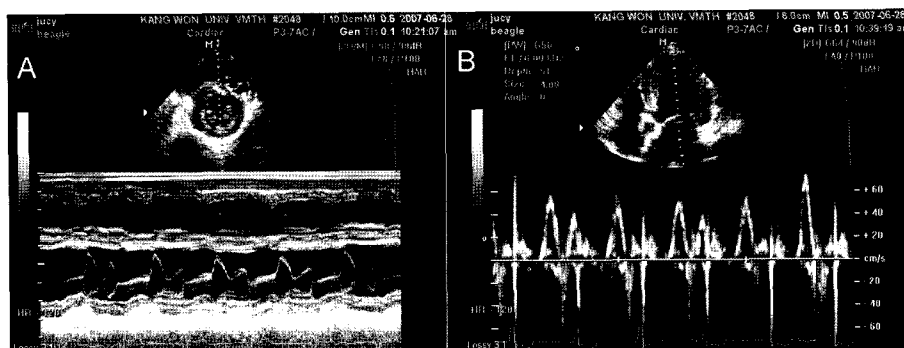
Echocardiography taken after pacemaker implantation. A: The M-mode echocardiogram showed regular and consistent left ventricular contraction. B: Spectral Doppler echocardiogram showed consistent coupling of E and A wave. The E wave is a larger and laminar flow. There was no absence of the E wave after pacemaker implantation.
